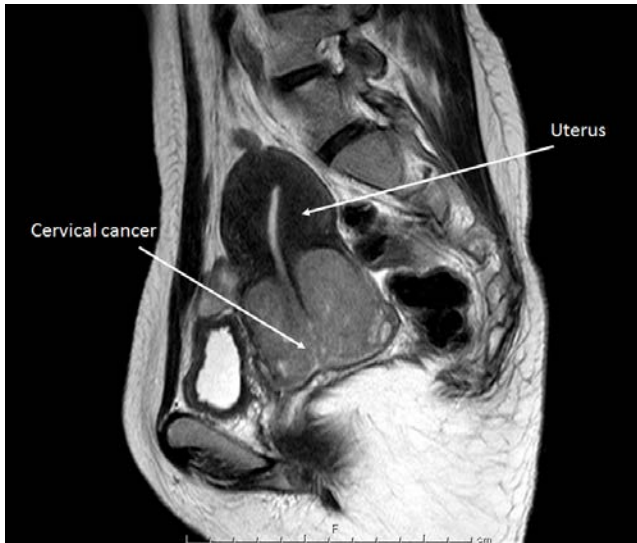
T2-weighted image of magnetic resonance imaging (MRI) showing the >60-mm tumor at the uterine cervix of the patient, a 45-year-old Japanese woman. No infiltration to a cardinal ligament or enlarged lymphocyte was detected in this MRI.
